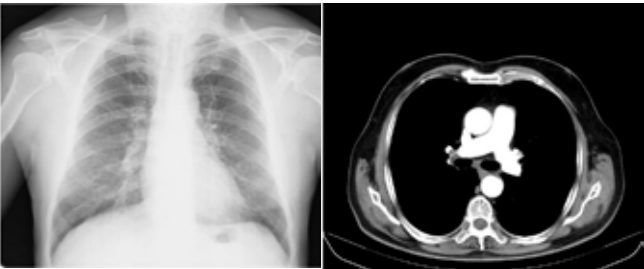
PA chest radiography and thoracic CT images of bilateral pulmonary vascular dilatations (a,b).
